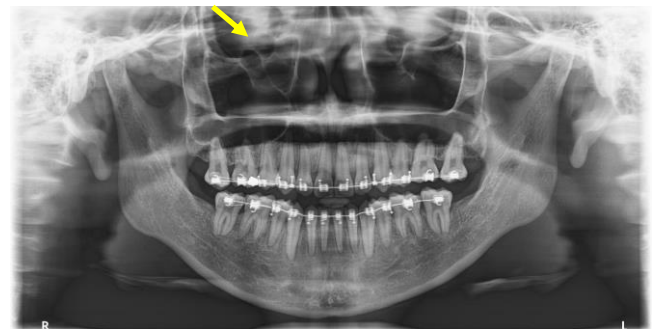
Panoramic radiograph showing multilocular pattern of Haller's cells on right side (arrow).
